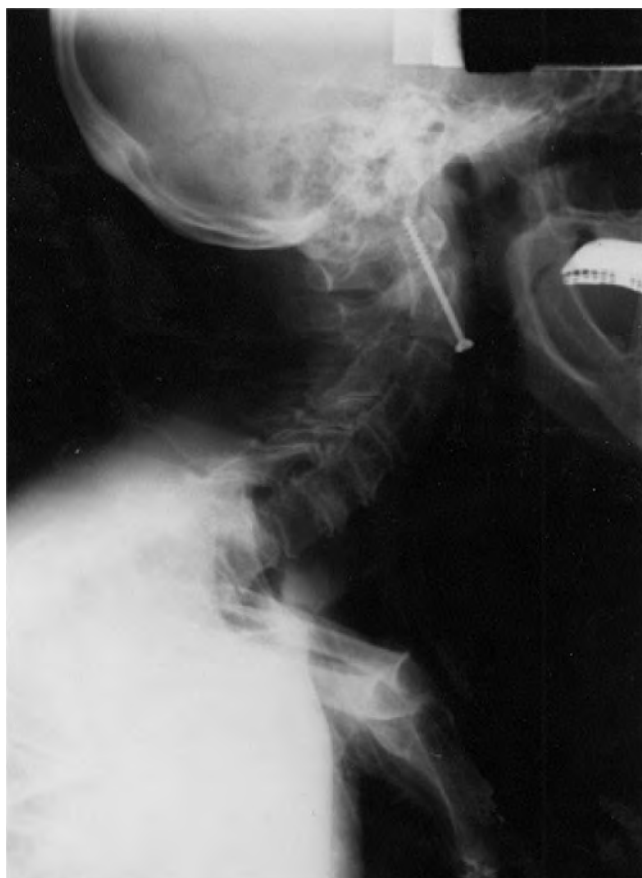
Lateral cervical X-ray showing a screw inserted to stabilize an acutely fractured odontoid peg.
